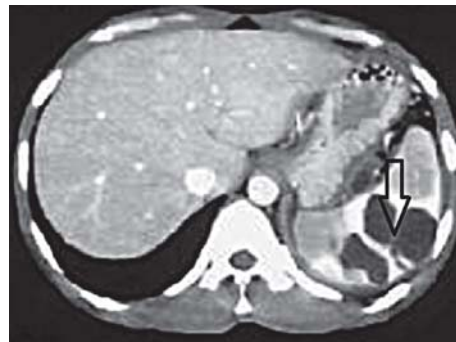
CT: cyst of the spleen (arrow)*
